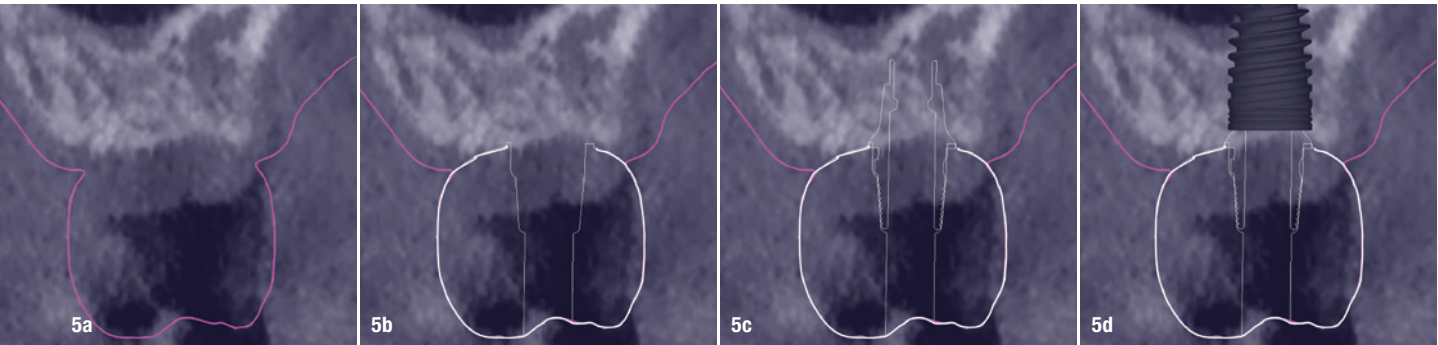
Implementation of the enhanced merging methodology at prosthesis delivery. Superimposition of the intra-oral scan taken at prosthesis delivery (purple line) on the pre-op CBCT scan (the right side is the buccal side) (a). Merging of the STL file of the crown (white line) in addition (b). Merging of the STL file of the prosthetic abutment (thin white line) with the previous superimposition (c). Merging of the STL file of the implant according to its height in addition (d).
